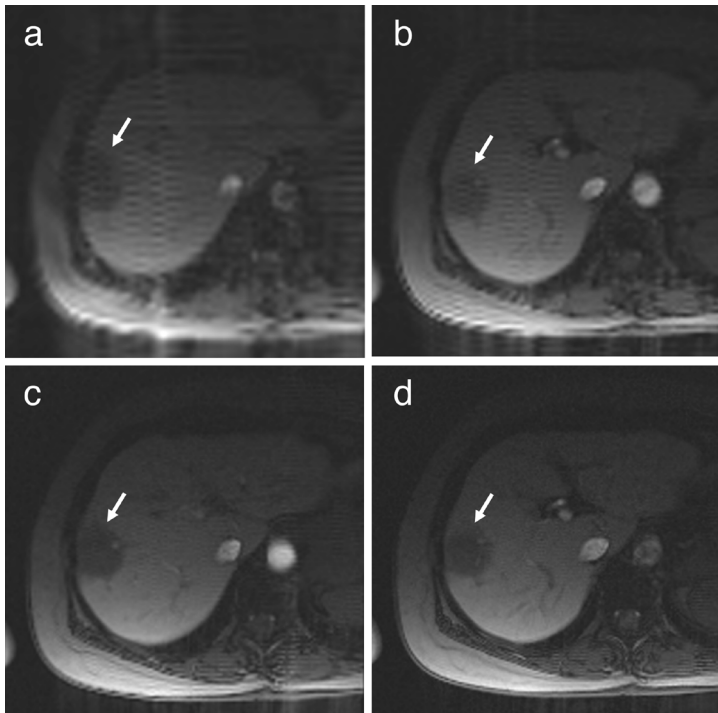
Measurement series 4. Real-time T1-weighted gradient-recalled echo sequences showing axial planes with different matrix sizes: 96 × 96, 128 × 128, 192 × 192, and 256 × 256 (a–d). Note the difference in the conspicuity of hypointense target lesion (arrows) and vascular structures and the different extent of artifacts.
